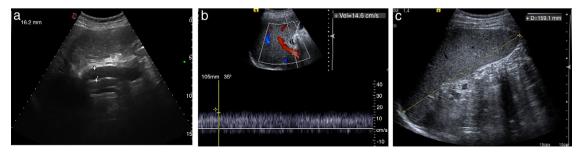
Seventy-three-year-old patient on ultrasound follow-up due to hepatic cirrhosis and portal hypertension. The ultrasound longitudinal plane on the portal vein (a) shows an increased portal caliber (16 mm). The Doppler spectrum conducted at hepatic hilum level on one right intercostal plane (b) shows reduced portal velocity (14.6 cm/s). Finally, one longitudinal plane on the spleen (c) shows one 16 cm-splenomegaly.
